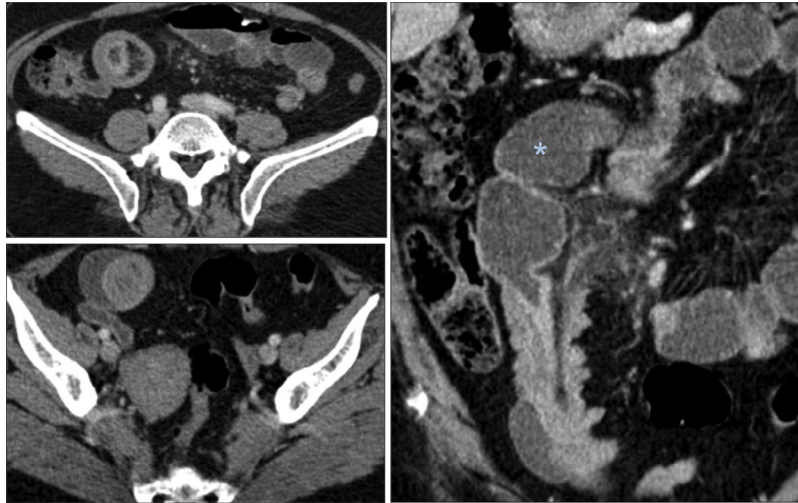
Contrast-enhanced computed tomography (CT) scan. Axial images (left panel) and coronal view (right panel) depict bowel-in-bowel appearance of intussusception. Note dilatation of bowel loops proximal to the intussusception (asterisk). There was no free peritoneal fluid, lymphadenopathy, or liver metastasis.
